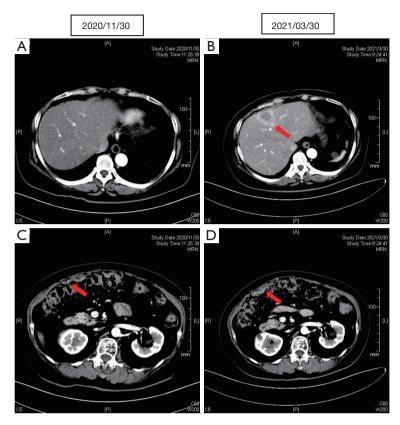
Contrast-enhanced CT imaging of the abdomen imaging after 22 (A) and 26 (B) cycles of treatment. Compared with *Figure 6A, Figure 6B* shows abnormal mass density in the left lobe of the liver (red arrows; about 3.3 cm × 2.2 cm). (C) Slightly thickened right peritoneum (red arrow); (D) multiple nodular thickening with enhancement, especially in the lower right abdomen, with the largest nodule (red arrow; 1.8 cm in diameter). CT, computed tomography; A, anterior; R, right; L, left; P, posterior.
